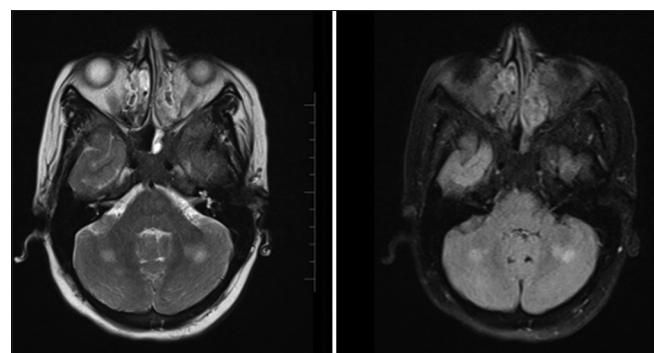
T2 and FLAIR sequences showing bilateral cerebellar hyperintensities
